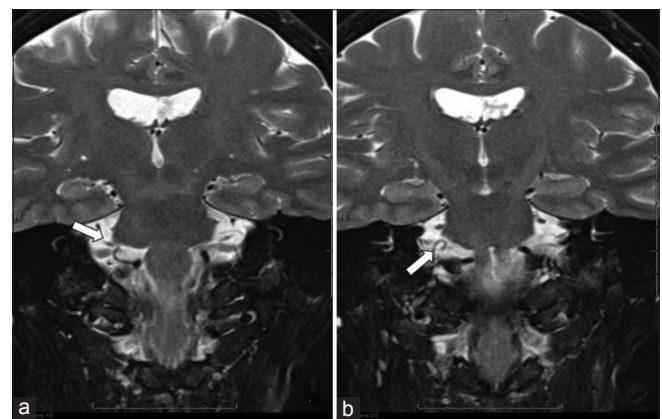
(a and b) T2-weighted Brain MRI (coronal plane). T2 Coronal MRI thin-section 3D CISS images showing the right PICA crossing the cerebello-pontine cistern in close contact with the right VII and VIII nerves. The arrow indicates the PICA loop
